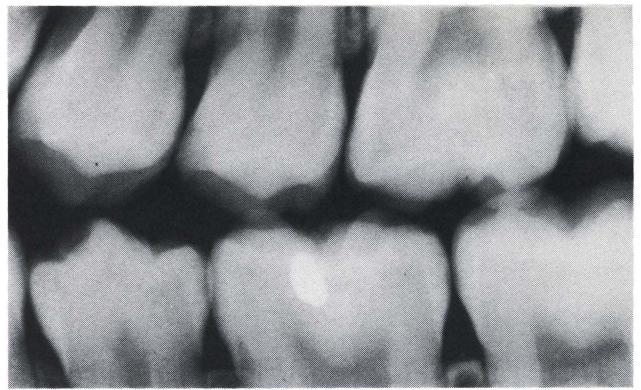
Bitewing radiograph from a twelve-year-old girl. The distal surface of the maxillary left second premolar showed a microcavity; the mesial surface, a white spot.
